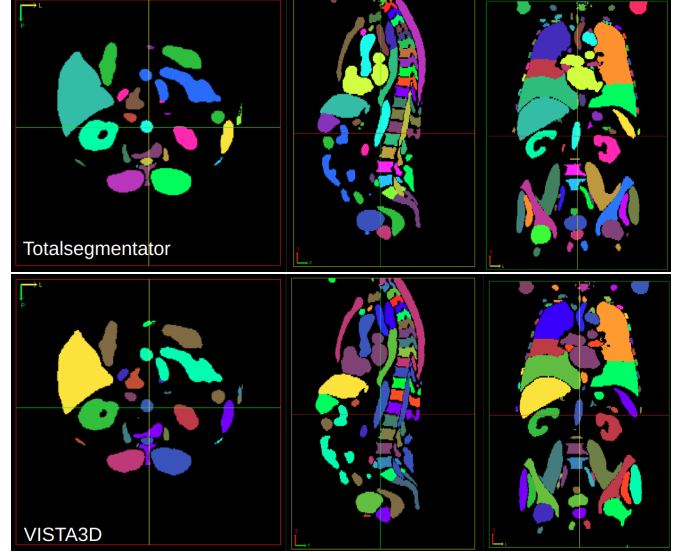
An example of whole class segmentation on a typical sized human CT scan. Running on a lower end machine with 12GB GPU. The runtime for VISTA3D is 1m43s and 2m41s for TotalSegmentator.
